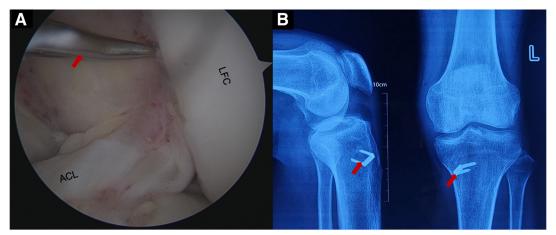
Microfracture and graft fixation. (A) Arthroscopic pictures demonstrating microfracture in the lateral femoral condyle, anterior to anterior cruciate ligament attachment using a 4-mm microfracture awl (red arrow). (B) Postoperative radiograph of left knee anteroposterior and lateral view demonstrates bone staple application (red arrows).
